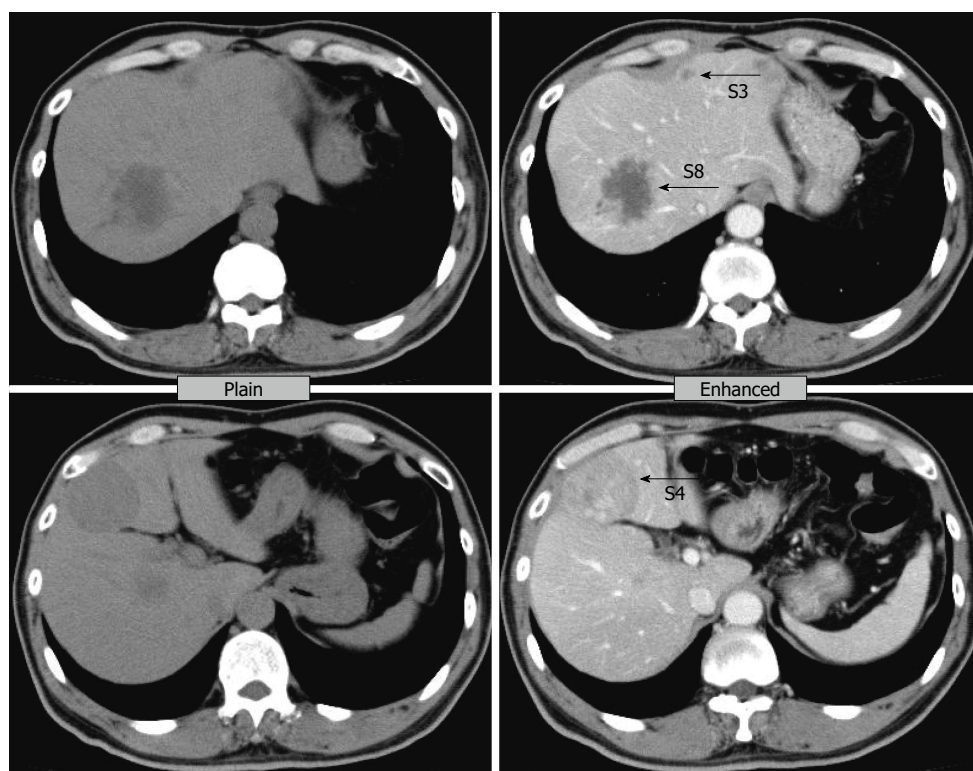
Computed tomography before treatment. An abdominal computed tomography scan revealed liver tumors in Segment 3, Segment 4, and Segment 8. The tumor in Segment 8 is hypodense with peripheral enhancement. The tumor in Segment 4 is a well-defined isodense tumor with homogeneous enhancement.
